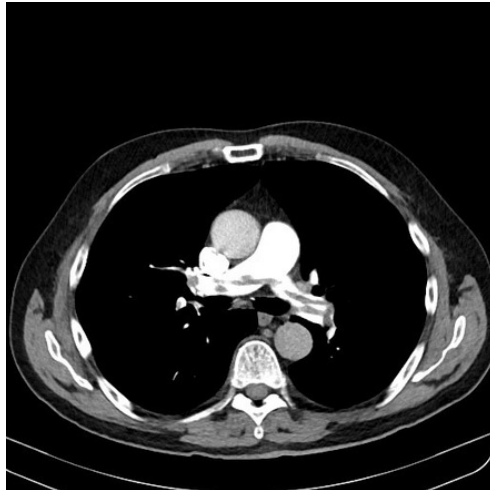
CT with PE presented on the Central Side of the Image.
